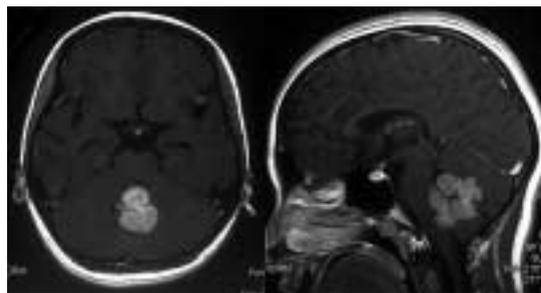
MR imaging disclosing 4th ventricle tumor.
